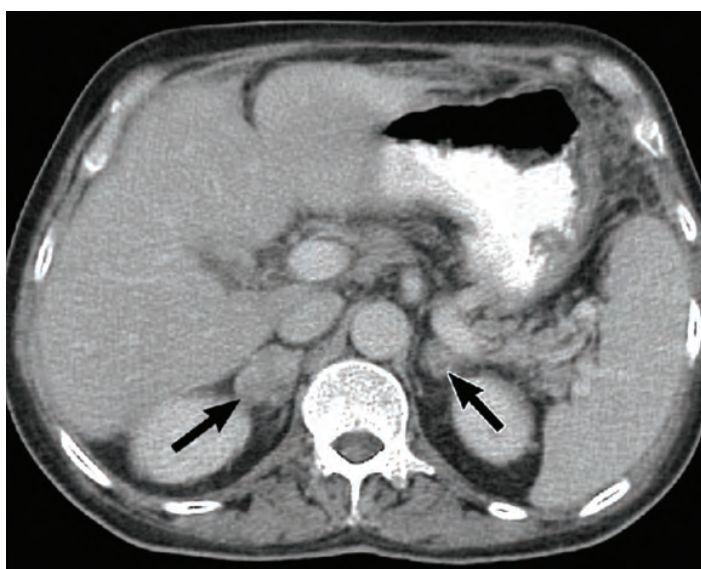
showing CT scan of the abdomen
